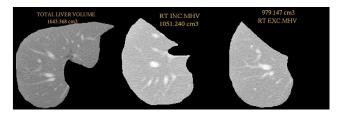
CT Volumetry images representing TLV, RT+MHV and RT-MHV respectively
